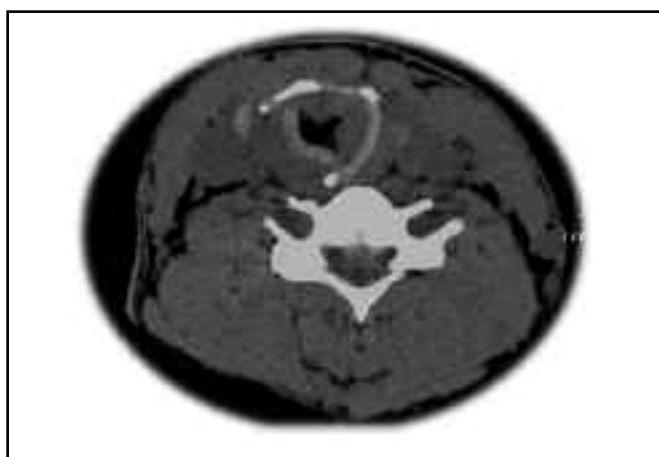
CT scan during phonation showed rotation of the inlet axis to the left.
